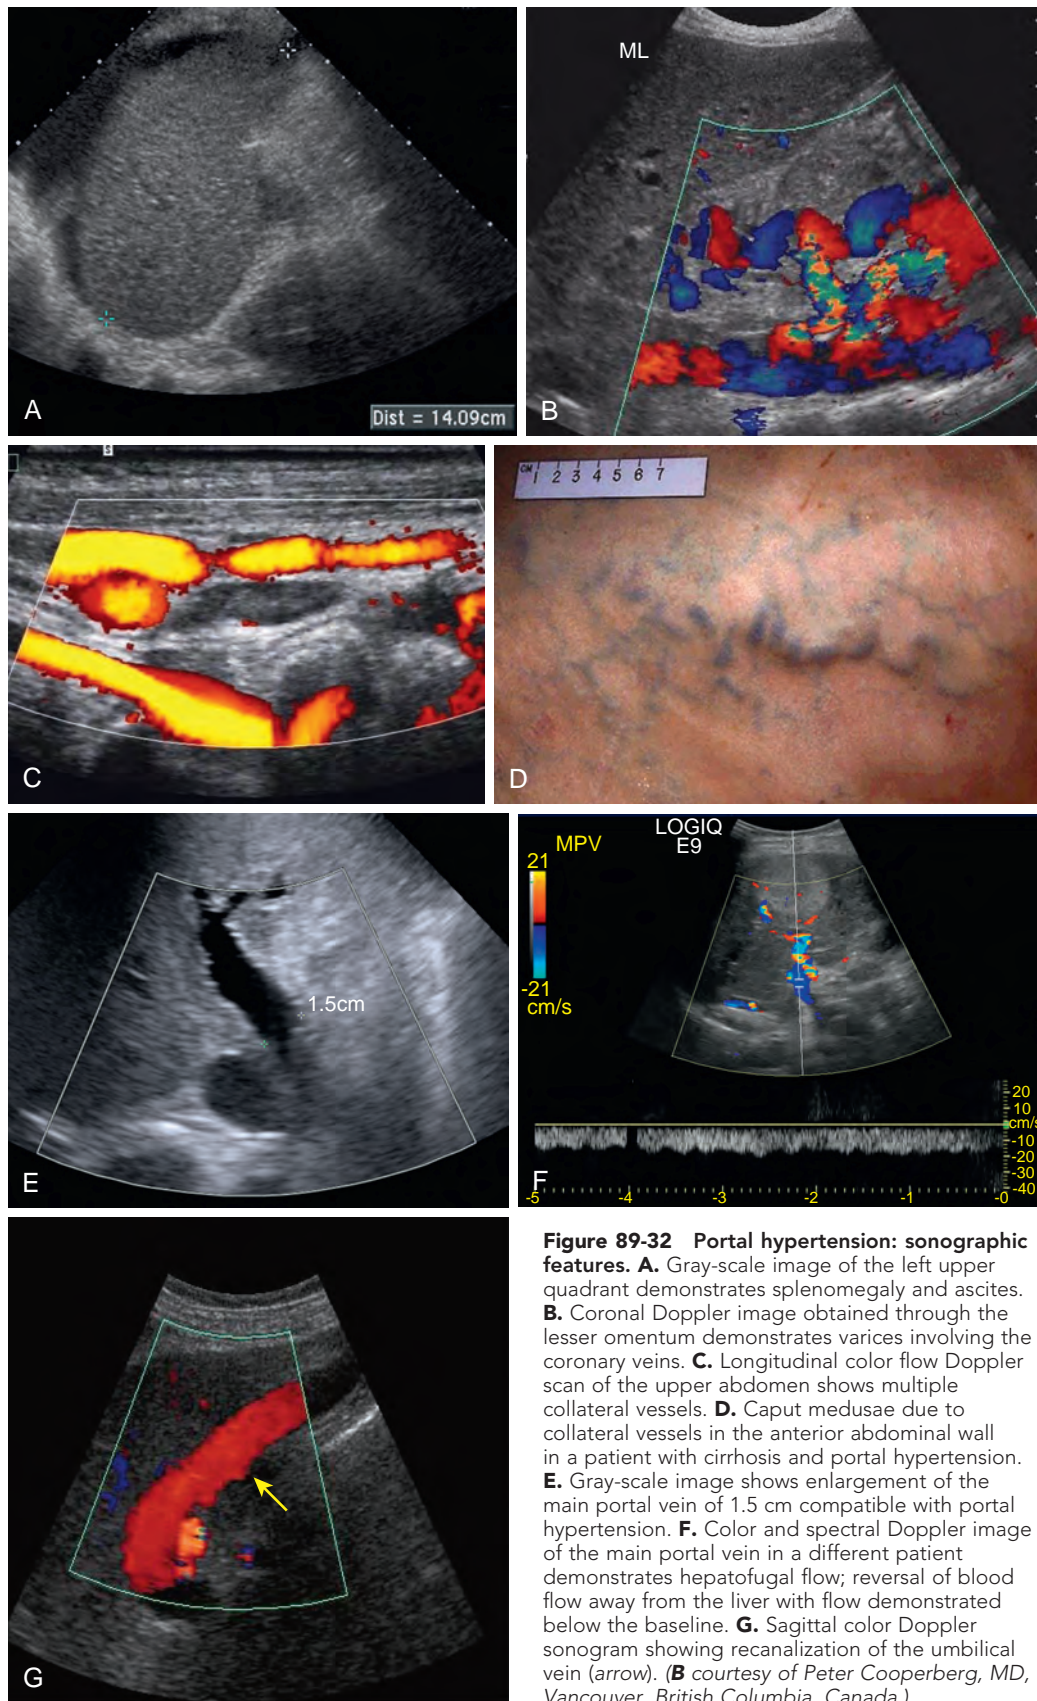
Portal hypertension: sonographic features. A. Gray-scale image of the left upper quadrant demonstrates splenomegaly and ascites. B. Coronal Doppler image obtained through the lesser omentum demonstrates varices involving the coronary veins. C. Longitudinal color flow Doppler scan of the upper abdomen shows multiple collateral vessels. D. Caput medusae due to collateral vessels in the anterior abdominal wall in a patient with cirrhosis and portal hypertension. E. Gray-scale image shows enlargement of the main portal vein of 1.5 cm compatible with portal hypertension. F. Color and spectral Doppler image of the main portal vein in a different patient demonstrates hepatofugal flow; reversal of blood flow away from the liver with flow demonstrated below the baseline. G. Sagittal color Doppler sonogram showing recanalization of the umbilical vein (arrow). (B courtesy of Peter Cooperberg, MD, Vancouver, British Columbia, Canada.)
